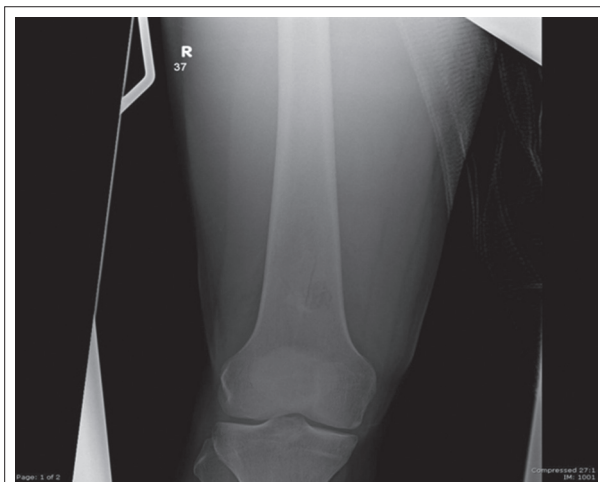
Radiograph of femur shows breach in distal one third of femur in anterior cortex.
